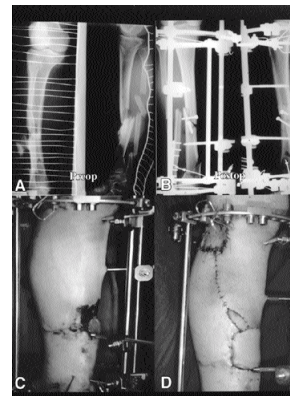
(A) The preoperative AP and lateral radiographs of 42-year-old man with a segmental distal shaft tibiofibular fracture of Gustilo open type b. (B) Immediate postoperative AP and lateral radiographs with hybrid external fixation(half pin, olive pin, lag screws and AnyFixR). (C,D) At 5 weeks after operation, saphenous flap operation without change of external fixator was done.
